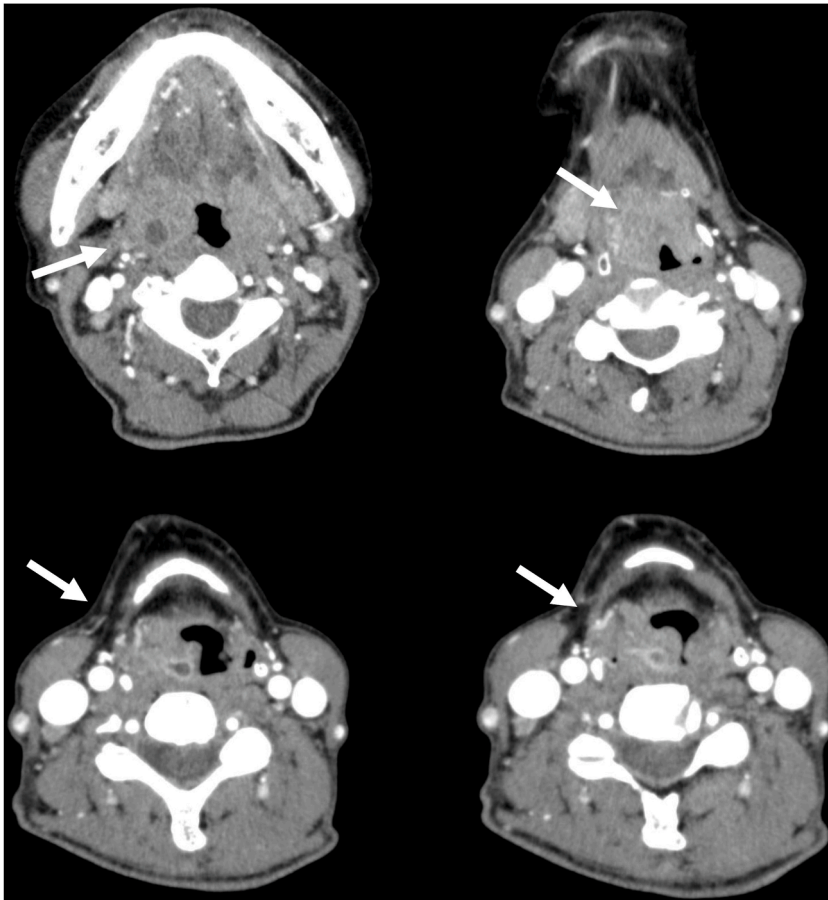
Contrast enhanced computed tomography of the neck (soft-tissue windows) showing swelling of the oropharyngeal wall, epiglottis and aryepiglottic fold with mild enhancement of contrast (white arrows).
